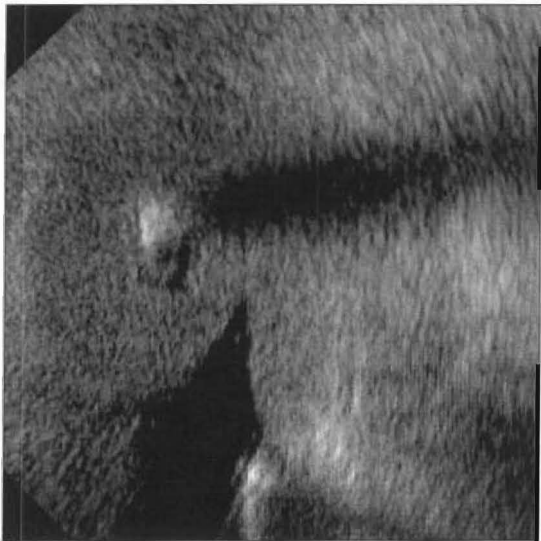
Original ultrasound image of female genital tract.
